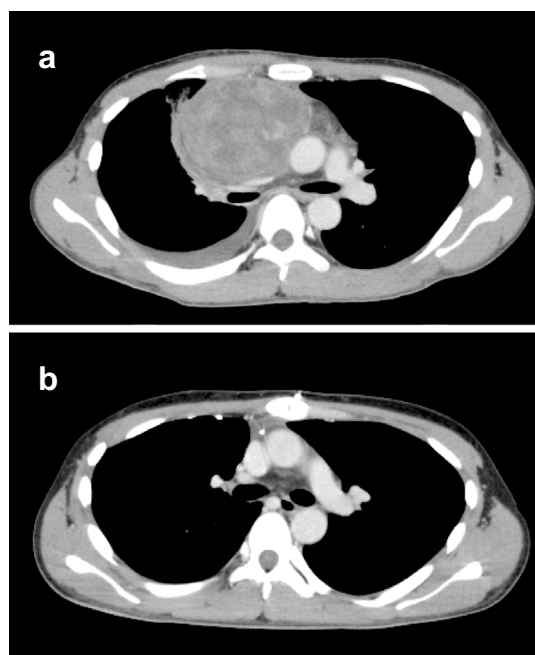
Computed tomography findings of the mediastinal germ cell tumor at the diagnosis (a) and at the presentation at our department (b).
